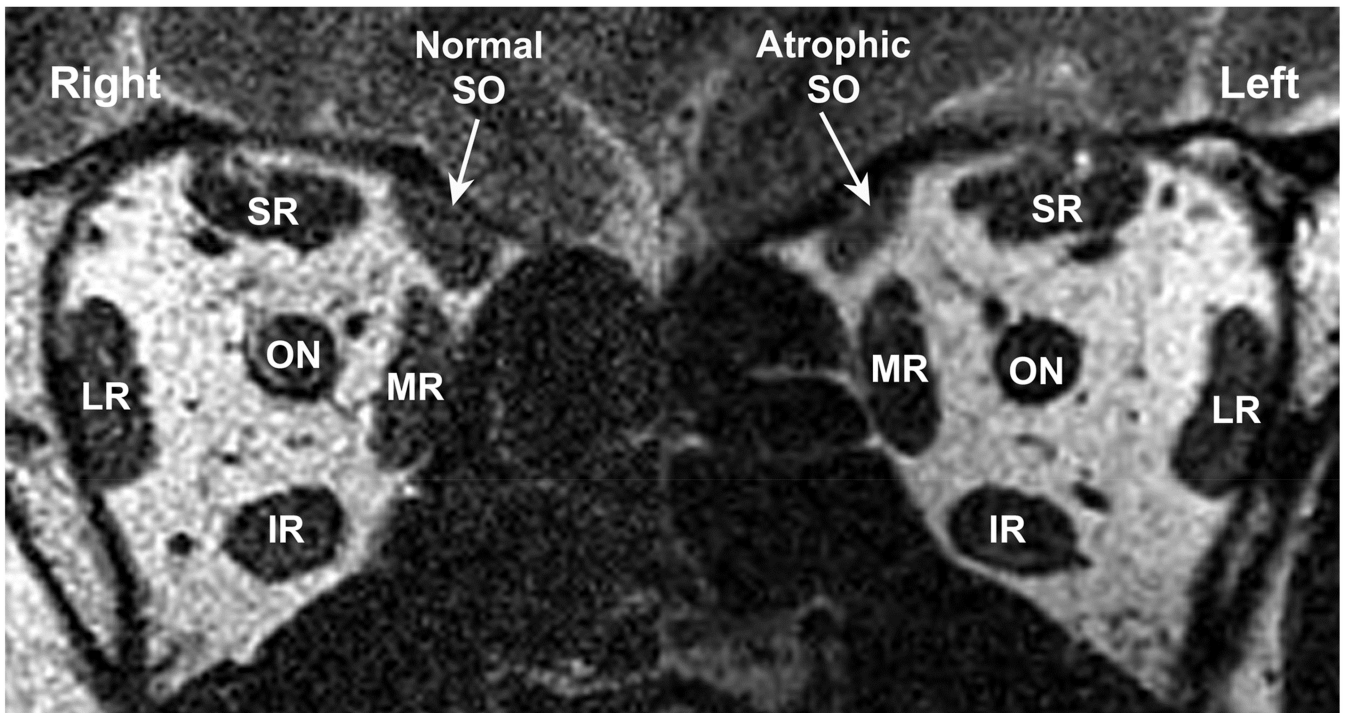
Surface coil MRI demonstrating anisotropic atrophy of the left superior oblique muscle (*SO*) in Case 8. *IR*, inferior rectus muscle; *LR*, lateral rectus muscle; *MR*, medial rectus muscle; *ON*, optic nerve; *SR*, superior rectus muscle. The atrophy thins the minor axis of the *SO* without altering the dimension of the major axis.
